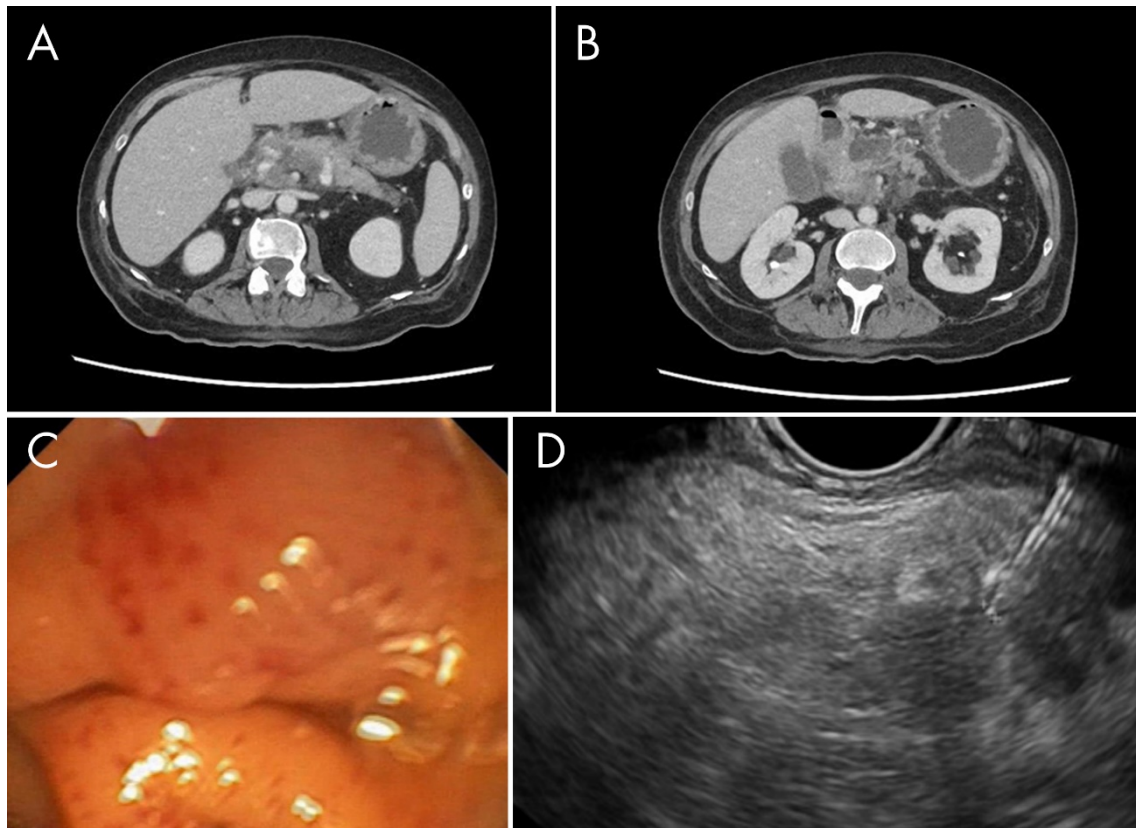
A and B: Abdominal CT demonstrating an acute necrotic collection involving the head and part of the pancreatic body, with minimal extension to the adjacent mesentery, measuring approximately 5.7x3.6 cm at its largest dimension. There is evidence of de-structuring of the pancreatic gland at the head-neck level, without dilation of the Wirsung duct. C: Edematous duodenal folds that partially narrow the lumen, hindering the identification of the papilla. D: Endoscopic ultrasound (EUS) reveals a pancreatic duct of normal caliber (2 mm at the body) that becomes indistinct at the body-isthmus junction. While no peripancreatic collection is observed at this level, complete ductal disruption cannot be definitively ruled out. Puncture of the duct at the body-tail junction (1.2 mm) is performed using a 22G needle.
